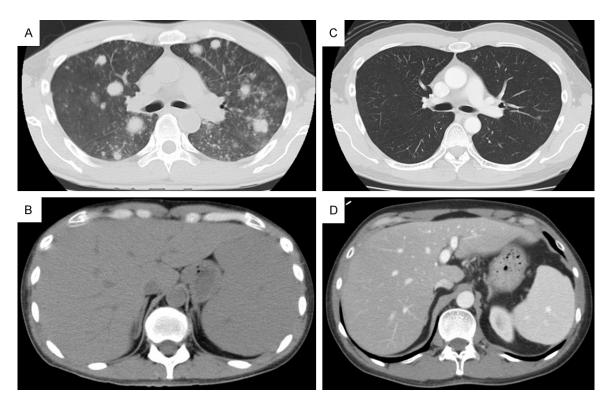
Computed tomography (CT) findings. A: Multiple, smooth-bordered, well-defined, large and small nodular shadows and granular shadows can be seen in both lung fields before treatment. B: Marked hepatosplenomegaly is present before treatment. C: The nodular shadows and granular shadows have disappeared after 4 courses of R-CHOP (rituximab, cyclophosphamide hydrate, doxorubicin hydrochloride, vincristine sulfate, and prednisolone). D: The hepatosplenomegaly improved after 4 courses of R-CHOP.
